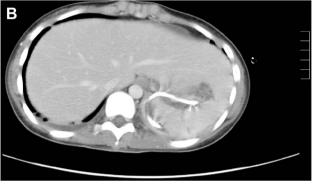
Follow-up abdominal computed tomography scan showing the inserted percutaneous drainage catheter in the abscess of the spleen; the sizes of the abscesses are decreased compared with those seen in the previous computed tomography scan.
